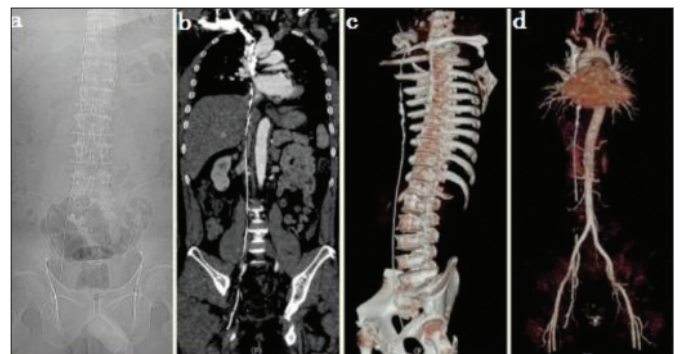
(a) A routine radiograph of the abdomen displayed a guide wire at the right border of the spine. (b) Coronal CT showing CVC guide wire in abdominal and pelvic cavity. (c) Three-dimensional CT showing the long guide wire of paraspinal from first rib to ischial. (d) CT angiography showing insertion of the guide wire from superior vena cava to right femoral vein.
